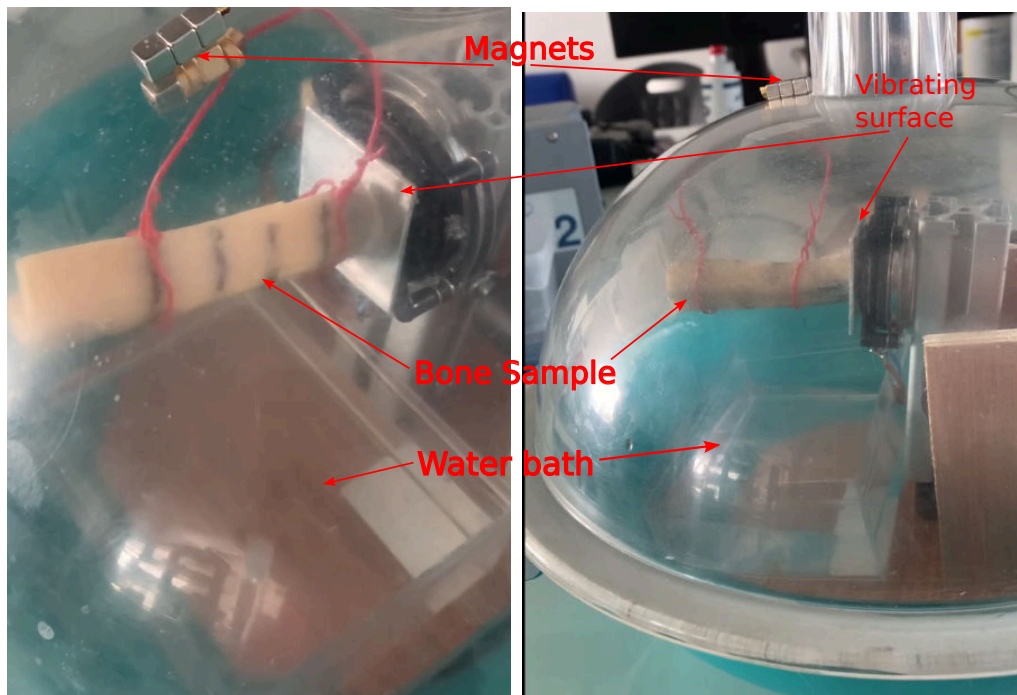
The homemade degassing setup implemented before ultrasound acquisitions to eliminate air from within the bone microstructure.
